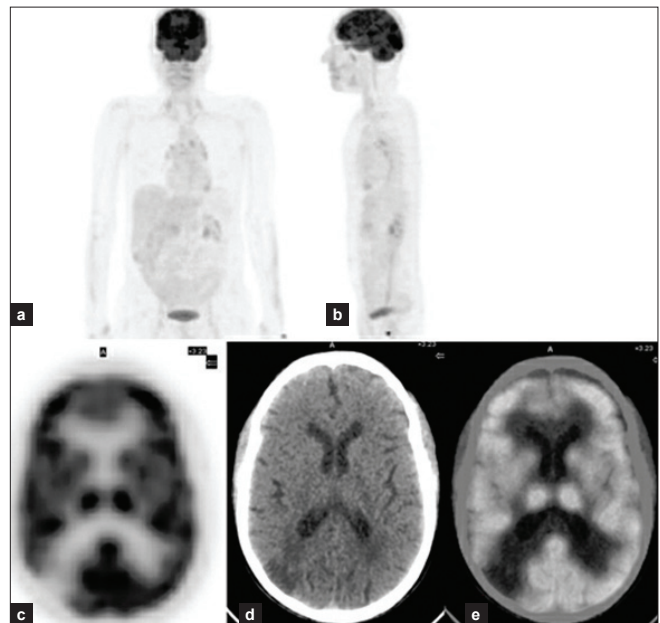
70-year male case of Ca larynx post-op post-RT on follow-up; (a, b) Anterior and lateral MIP image not remarkable; (c, d, e) Axial plain PET, CT and fused PET/CT images showing hypometabolism corresponding to a well-defined wedge shaped hypodense lesion involving grey and underlying white matter on CT in the right posterior parietal lobe suggestive of a chronic infarct
